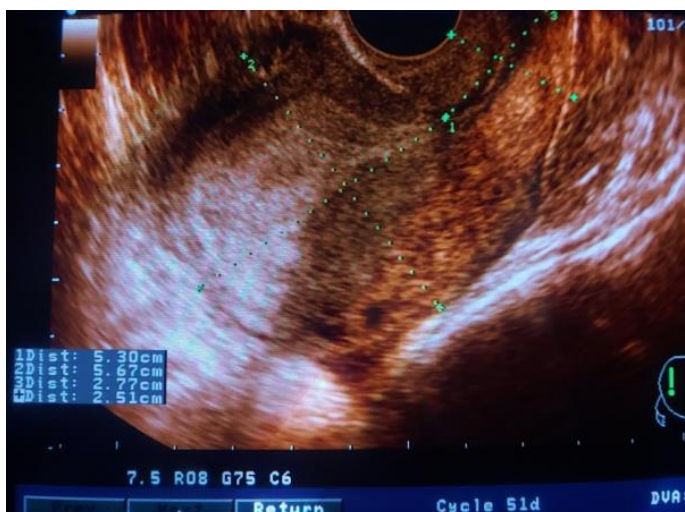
Longitudinal transvaginal sonographic image of the uterus
